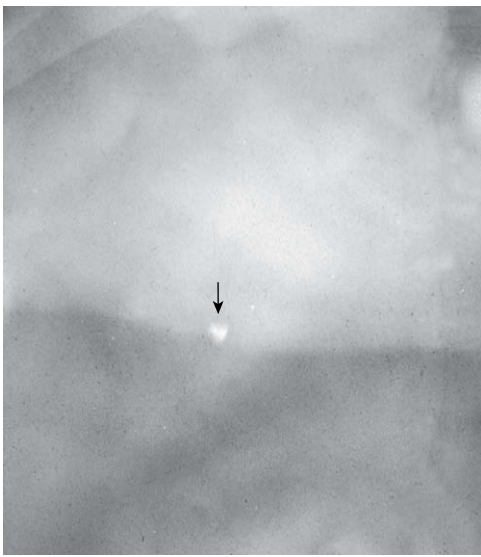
A, A 4-year-old girl fell, injuring her lip. She presented with an infected vesicle and hematoma. She had subluxation of both maxillary central incisors and a wound in the upper frenum. B, Radiograph of the lip showing several dental fragments embedded in the lip (*arrows*). The wound is also visible radiographically.
